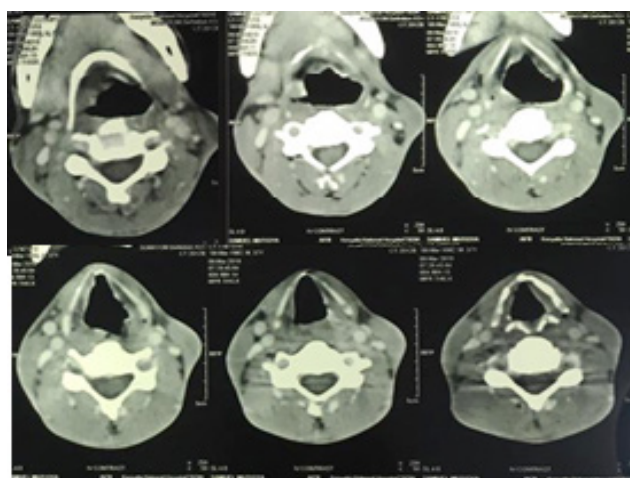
CT scan neck finding axial cuts showing fullness of left pyriform sinus with left supraglottic ulceration
